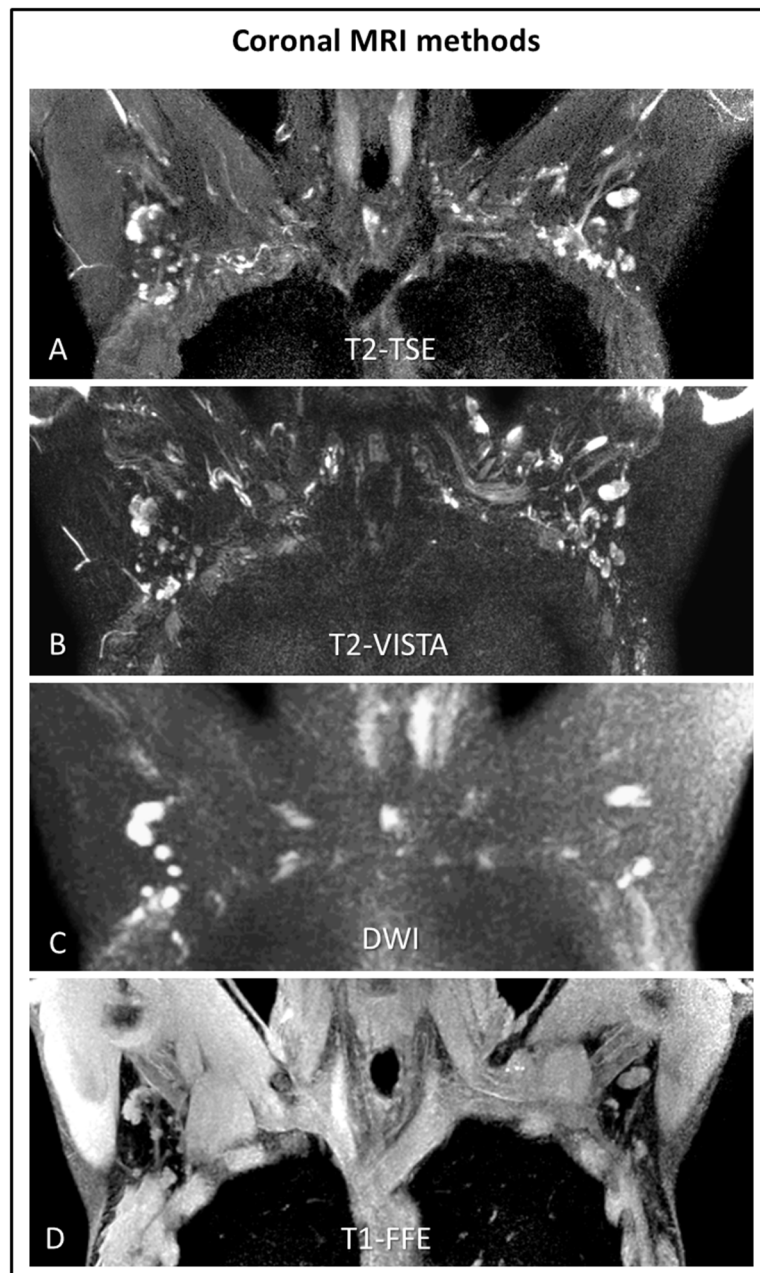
Examples of the four different non-reference MRI scans in one patient, acquired preoperatively in the coronal plane. Individual LNs and surrounding structures are visualized bilaterally. The patient is scanned in supine treatment position, i.e. with both arms in abduction, using T2-TSE ((A), Dixon-water), T2-VISTA (B), DWI ((C), $b = 800 \text{ s mm}^{-2}$), and T1-FFE ((D), Dixon-water). These methods were described in more details and evaluated previously (van Heijst *et al* 2016). *Abbreviations:* MRI = magnetic resonance imaging; LNs = lymph nodes; T2-TSE (T2-weighted turbo spin echo; T2-VISTA = T2-weighted volumetric isotropic acquisition; DWI = diffusion-weighted MRI; T1-FFE = T1-weighted fast field echo.
